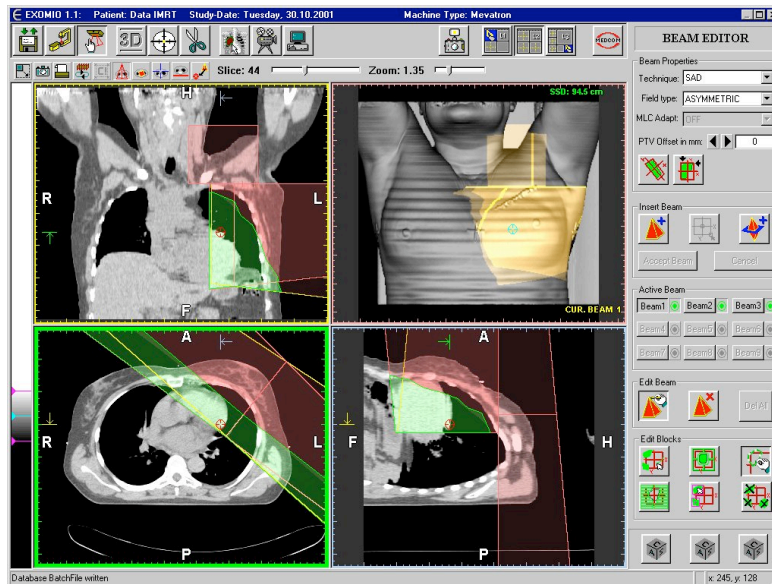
Planning procedure overview. (Top left) Coronal plane with the two opposing tangential fields and the anterior field. (Bottom left) CT slice at the thoracic region with the two tangential fields. (Bottom right) Sagittal plane with the two opposing tangential fields and the anterior field. (Top right) OEV showing the patient with the light fields projections on the mask and skin for all fields.
